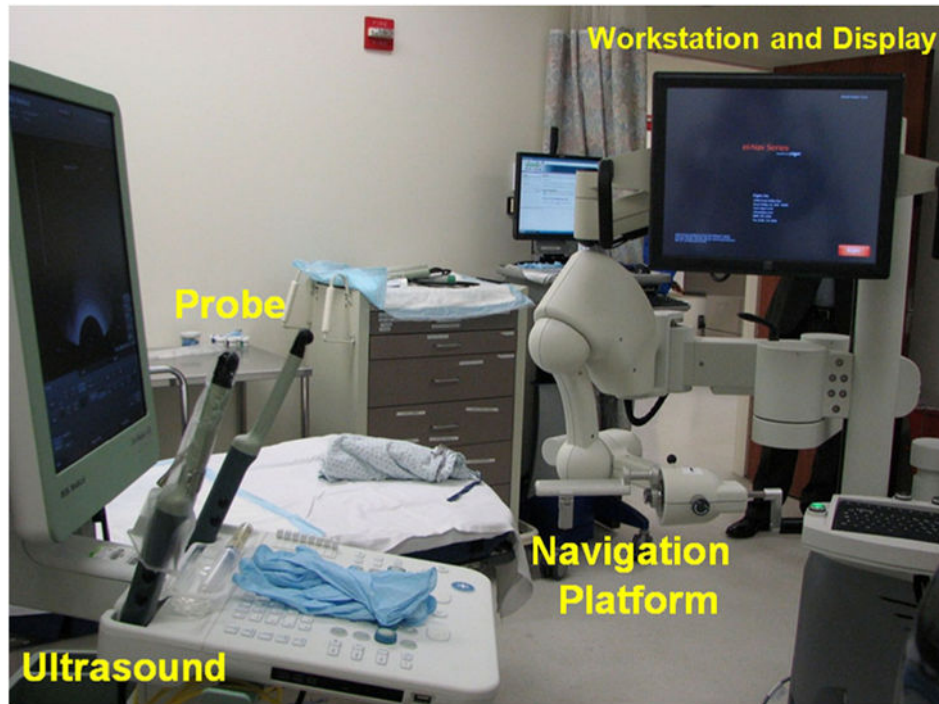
Setup for the molecular image-directed, 3D ultrasound-guided biopsy system that includes a commercial ultrasound scanner and an end firing probe from B&K Medical, the Artemis system, and a workstation for image fusion
